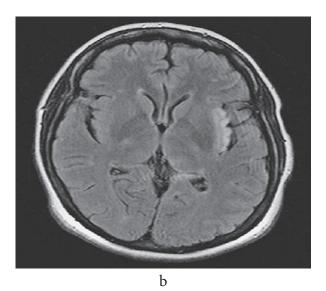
Brain MRI: extensive lesions in the left temporal lobe (a) and insularly on the left (b).
